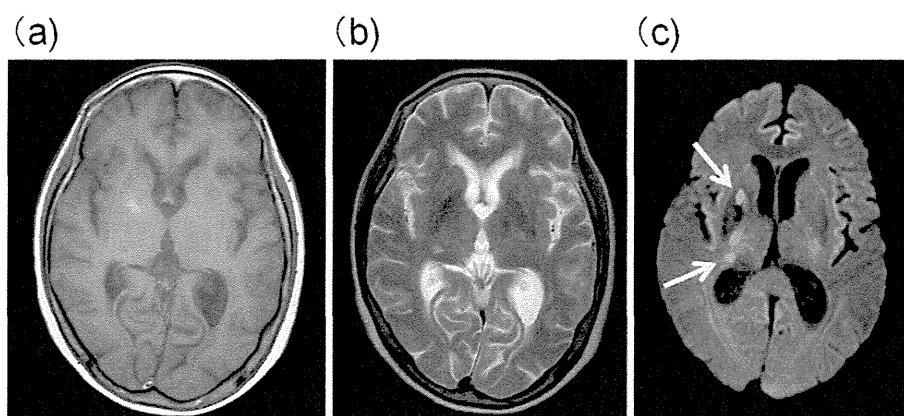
MRI findings of the right thalamus and caudate nucleus one month after admission. (a) T1WI. (b) T2WI. (c) DWI. High intensity signals (arrow) were observed.
